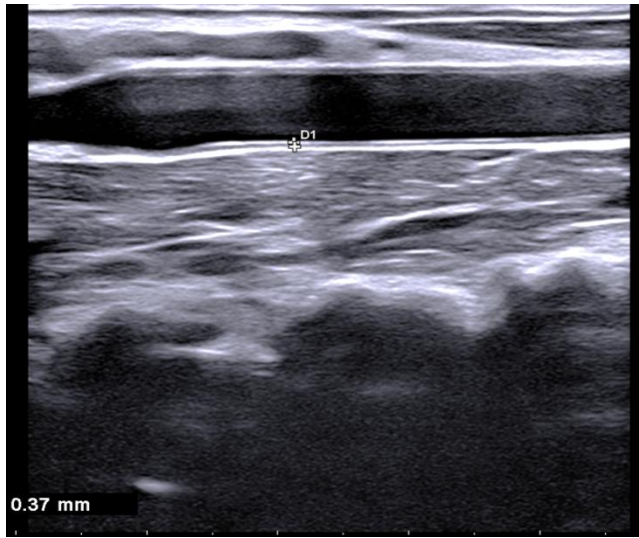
Representative sonographic image of CIMT measurement. Distance between two echogenic lines is measured in a plaque free region, about 10 mm proximal to the bifurcation.
